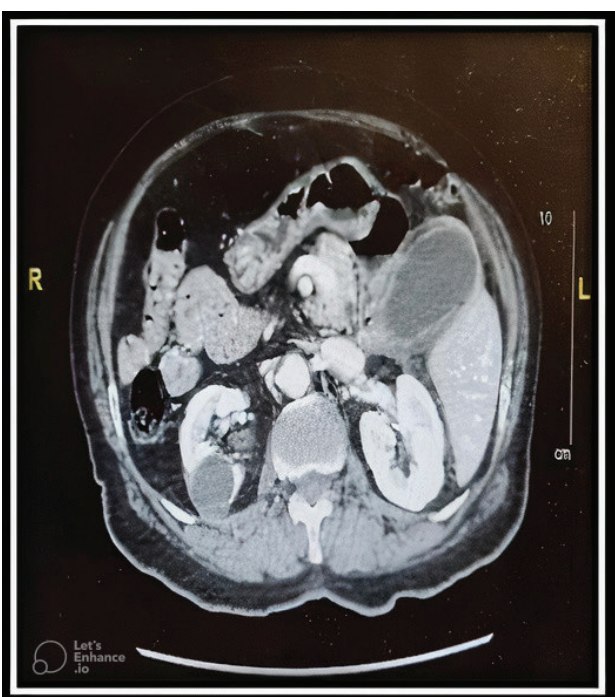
A CT that shows the liver, gallbladder on the left side.
